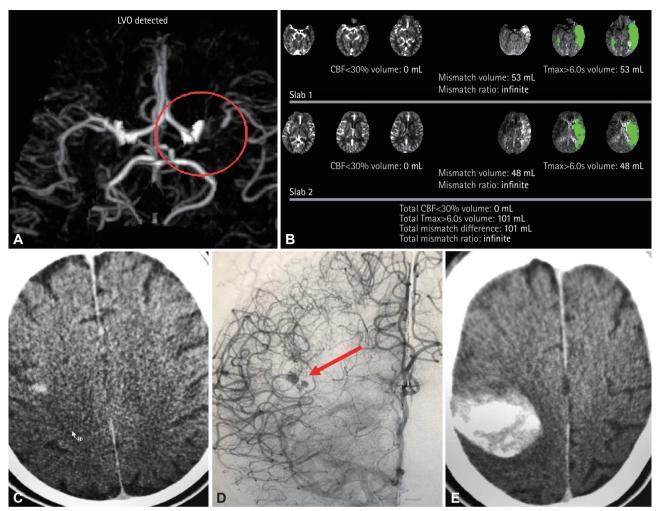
Brain CT, rapid automated processing of perfusion, and digital subtraction angiography. A and B: Brain CT rapid automated processing of perfusion software revealing left-middle cerebral artery occlusion with a 101-mL penumbra and no ischemic core. C: Follow-up brain CT depicting a small remote asymptomatic hemorrhage in the contralateral hemisphere. D: Digital subtraction angiography showing contrast extravasation in the right hemisphere with no underlying vascular lesion. E: Brain CT confirming the presence of a large remote parenchymal hematoma.
